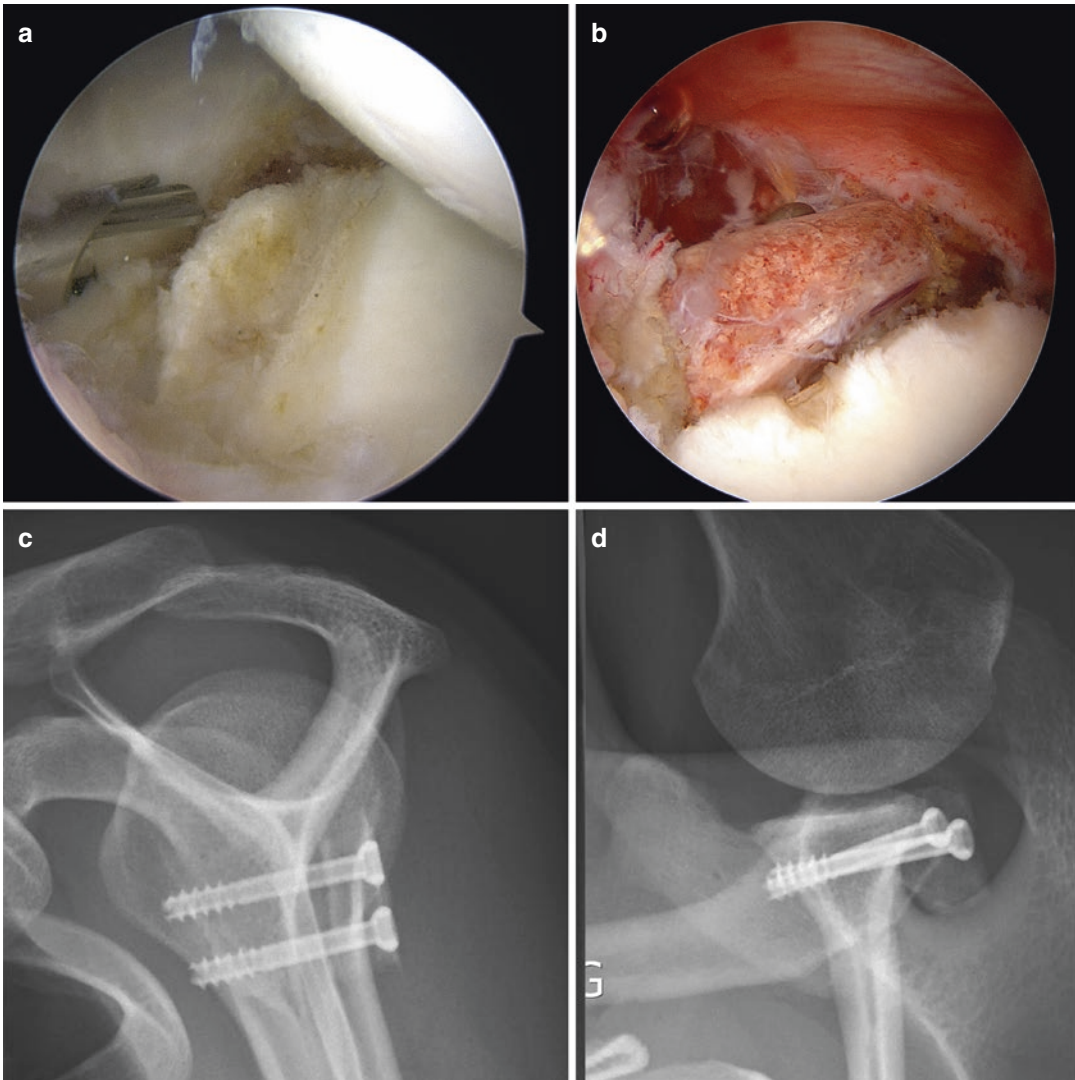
Malunited posterior bony Bankart (a) treated with posterior bone block arthroscopically placed (b). Postoperative radiographs show the final position of the iliac bone autograft (c, d)
